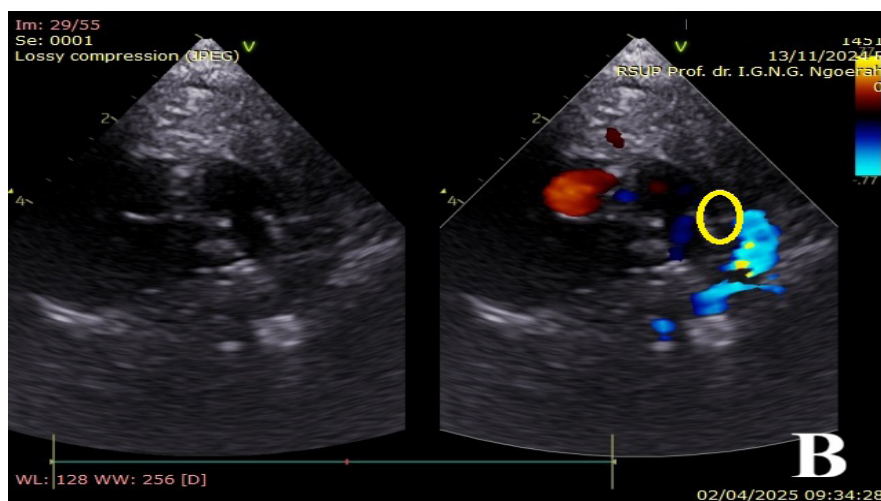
Echocardiographic suprasternal view demonstrating a ductal tunnel sign. The yellow circle indicates the closed ductal ampulla without detectable flow prior to intervention.
